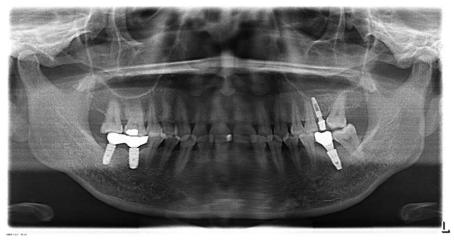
X-ray imaging 6 months after surgery.
